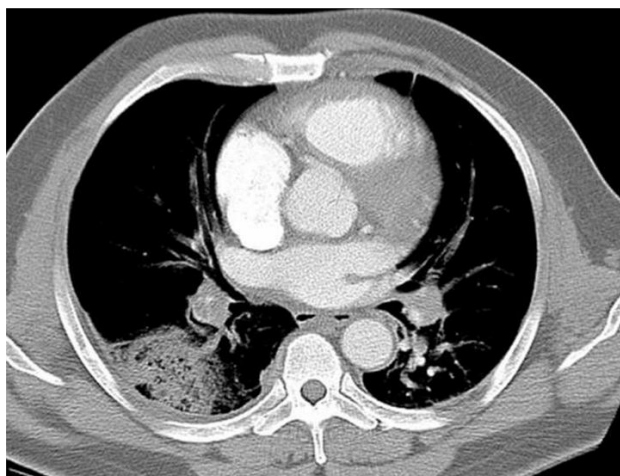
Patient, 44 year-old female, with acute pulmonary embolism. CT axial -consolidation with internal small air lucencies, suggestive of pulmonary infarction in the lower lobe of the right lung.
